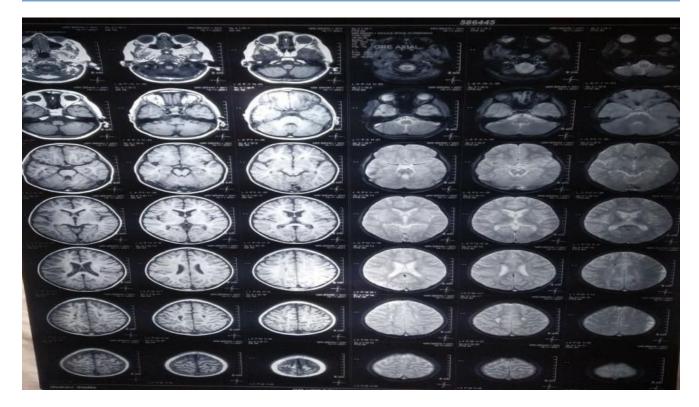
MRI brain of patient 6 - hyper intensities in bilateral cerebellar white matter, pons, anterior surface of medulla, mid brain.
